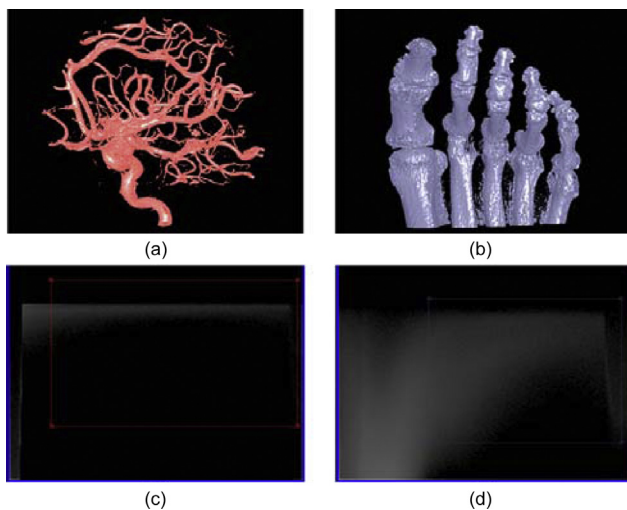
(a) The result of the aneurysm data (Fig. 1) used in Fig. 2(a) is rendered by transfer function set in (c). (b) The rendering image of a CT foot by using IS space (d), which can give more intuitive clues than the IGM space (see Fig. 12 in [7]).
